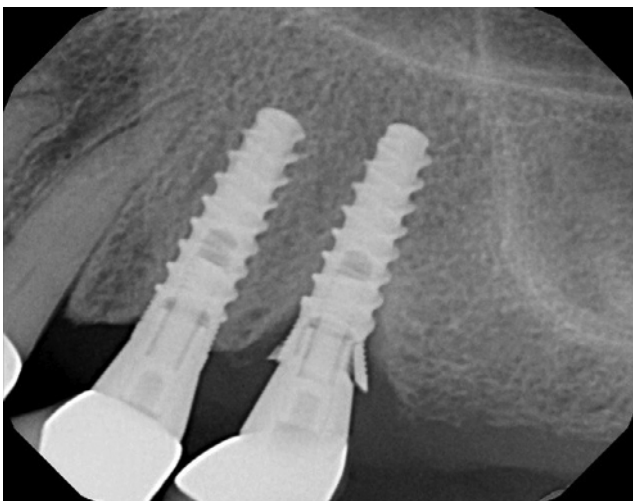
Radiograph of a fractured implant (no. 13). Note the mesial and distal bone loss, which usually precedes or accompanies a fractured implant.
